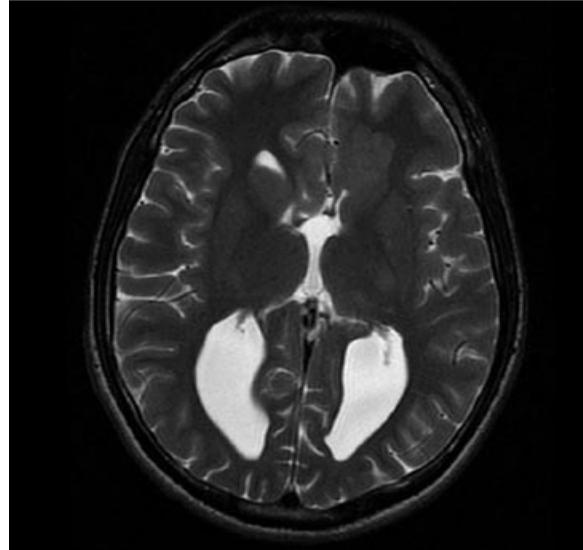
MRI, T2-weighted image, axial projection: typically dilated posterior horns of lateral ventricles and left frontal lobe focal pachygyria.
